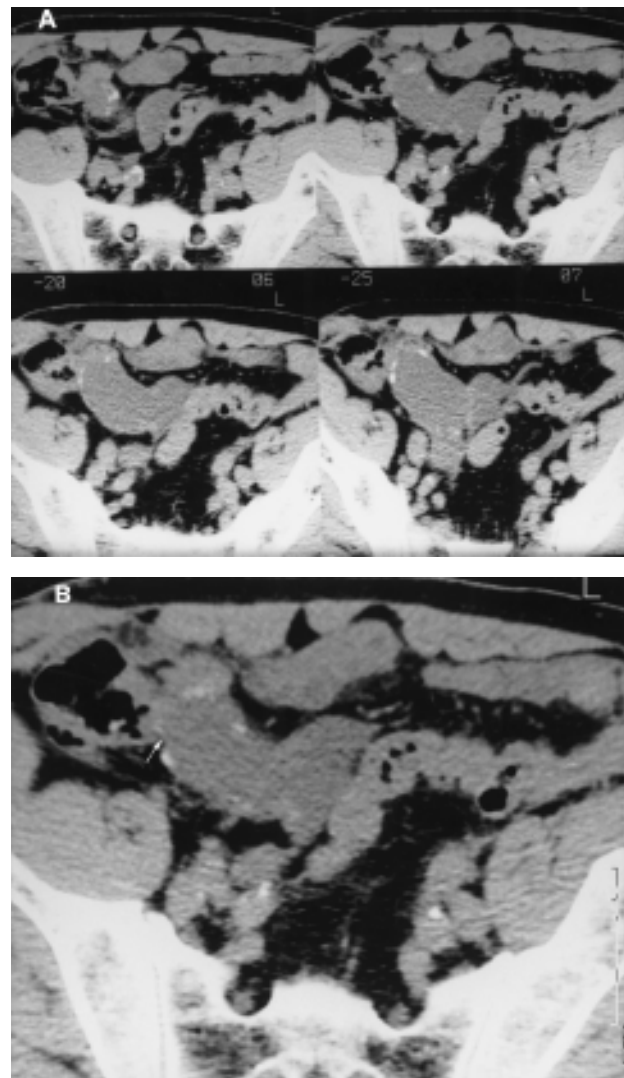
A. Axial CT scans with 5 mm slice thickness which clearly reveals a large appendiceal mucocele attached to the cecum, with some spotty calcifications of the wall. B. Axial CT scan (the second of the above scans) which shows the relationship of the cystic lesion to the cecum (arrow).
